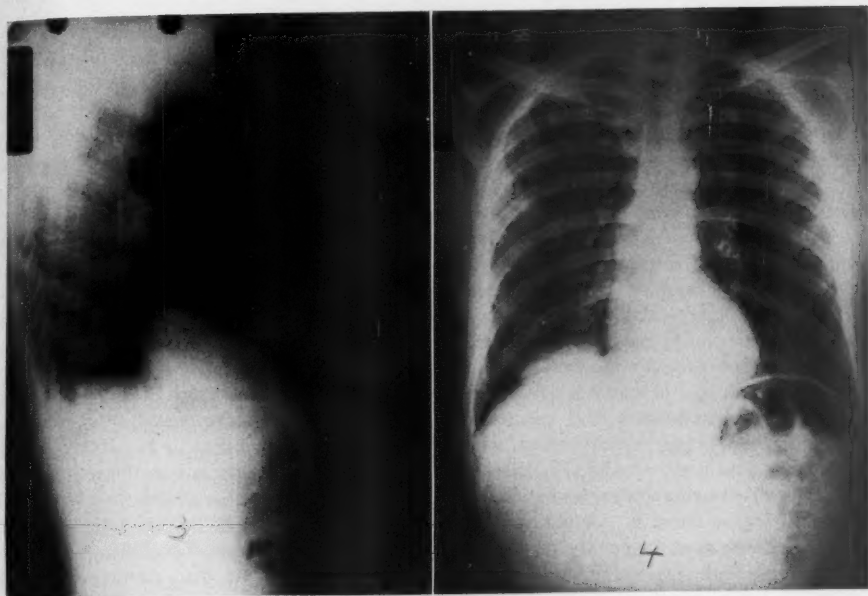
Case 9. Chest roentgenograms utilizing pneumoperitoneum to visualize liver in traumatic opening in right diaphragm.
